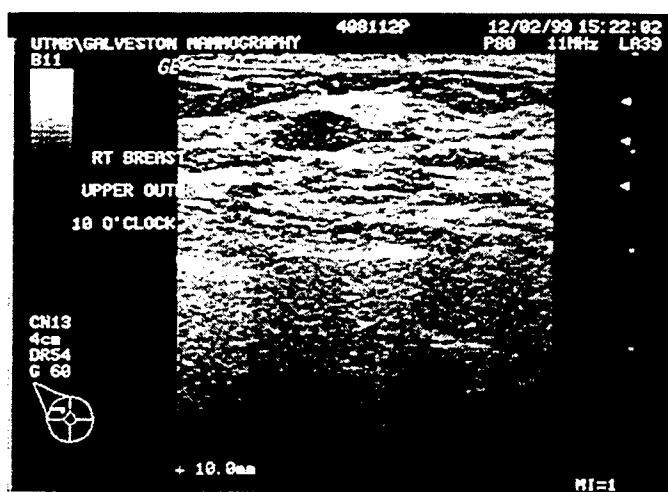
Ultrasound image of tumor UTMB Patient # 408112P.
